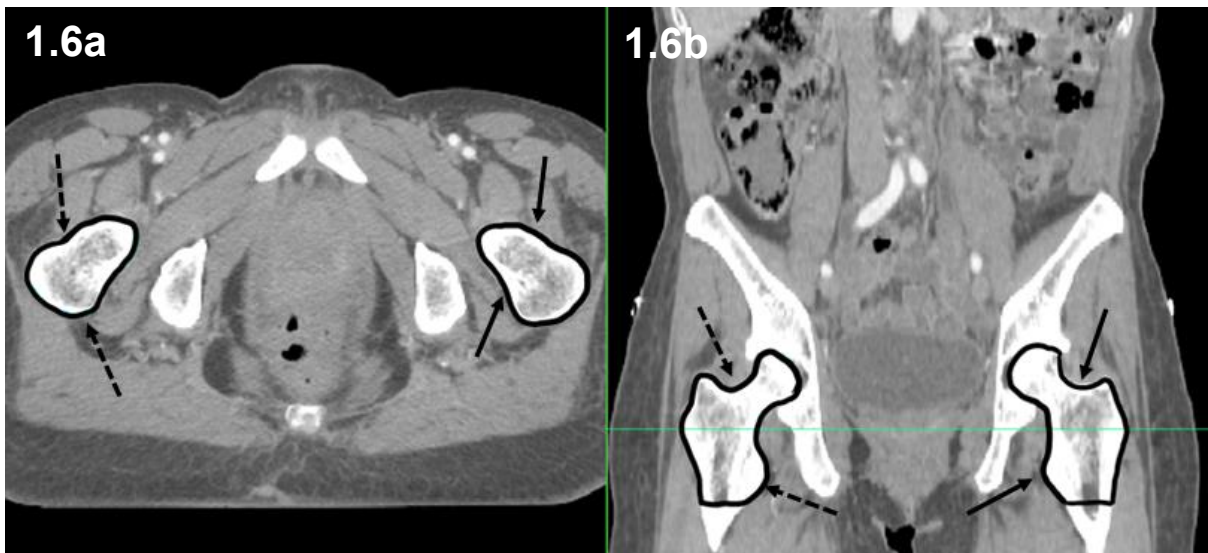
Transverse (a) and coronal (b) CT with left femur (solid arrows) and right femur (dashed arrows) outlined.
